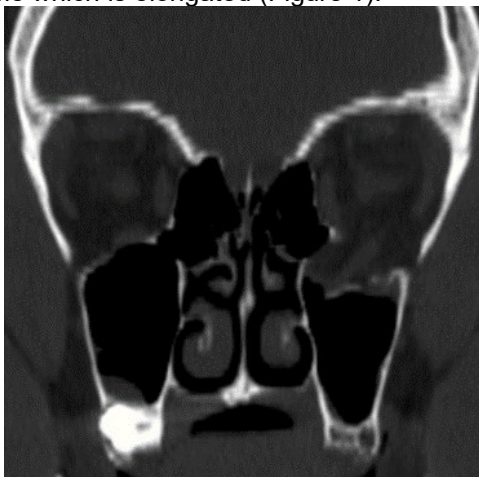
CT scan showing major fracture of left orbital floor with important herniation of the orbital soft tissues into the left maxillary sinus / CT scan care arată o fractură masivă a planșeului orbital stâng, cu herniere importantă a țesuturilor moi orbitare în sinusul maxilar stâng.
